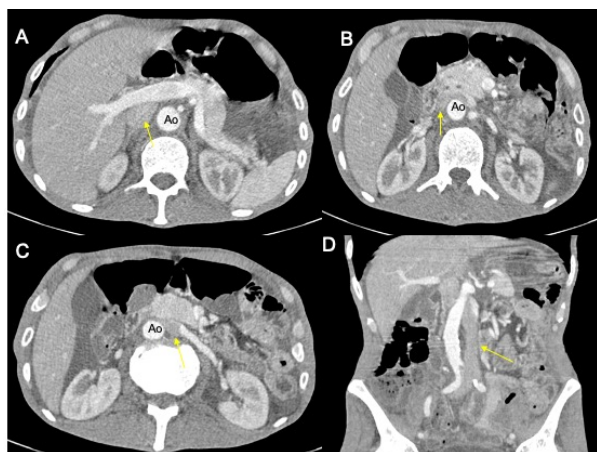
Abdominal CT scan in axial and (A-C) Coronal (D) Reconstructions, showing a left sided inferior vena cava (yellow arrow) placed on the left side of the abdominal Aorta (Ao).
